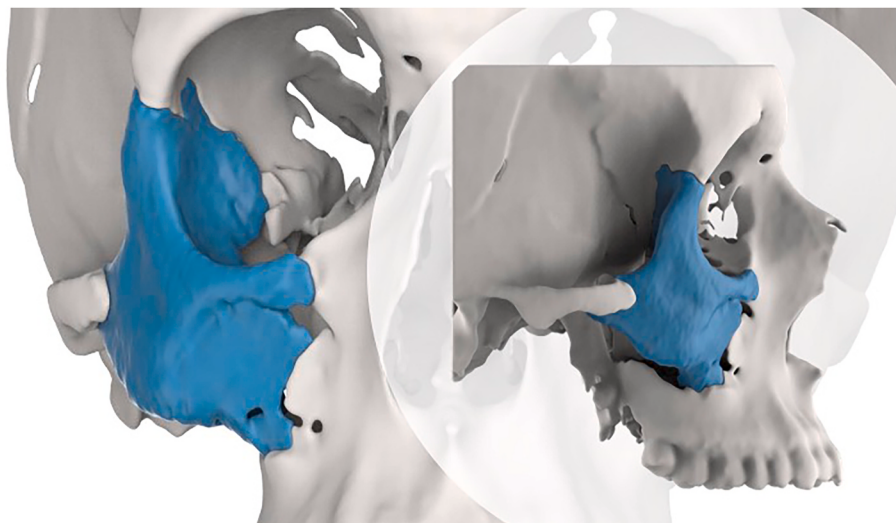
Representative figure from one of the patients, showing the preoperative situation, with the fracture highlighted. Extraction of data from the CBCT was performed virtually.
